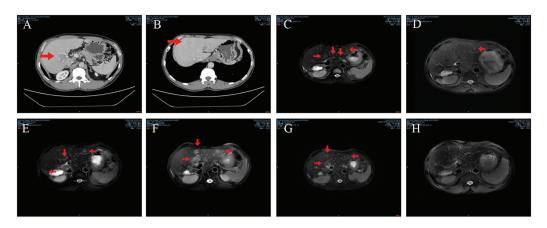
Imaging data during the treatment process. (A) Abdominal CT revealed a mass within the right hepatic lobe and VIII segment (B) before surgery. (C) MRI scan performed on October 2021. (D) MRI scan performed on November 2021. (E) MRI scan performed on February 2022. (F) MRI scan performed on May 2022. (G) MRI scan performed on July 2022. (H) MRI scan performed on October 2022. Arrow represents the location of the tumor.
